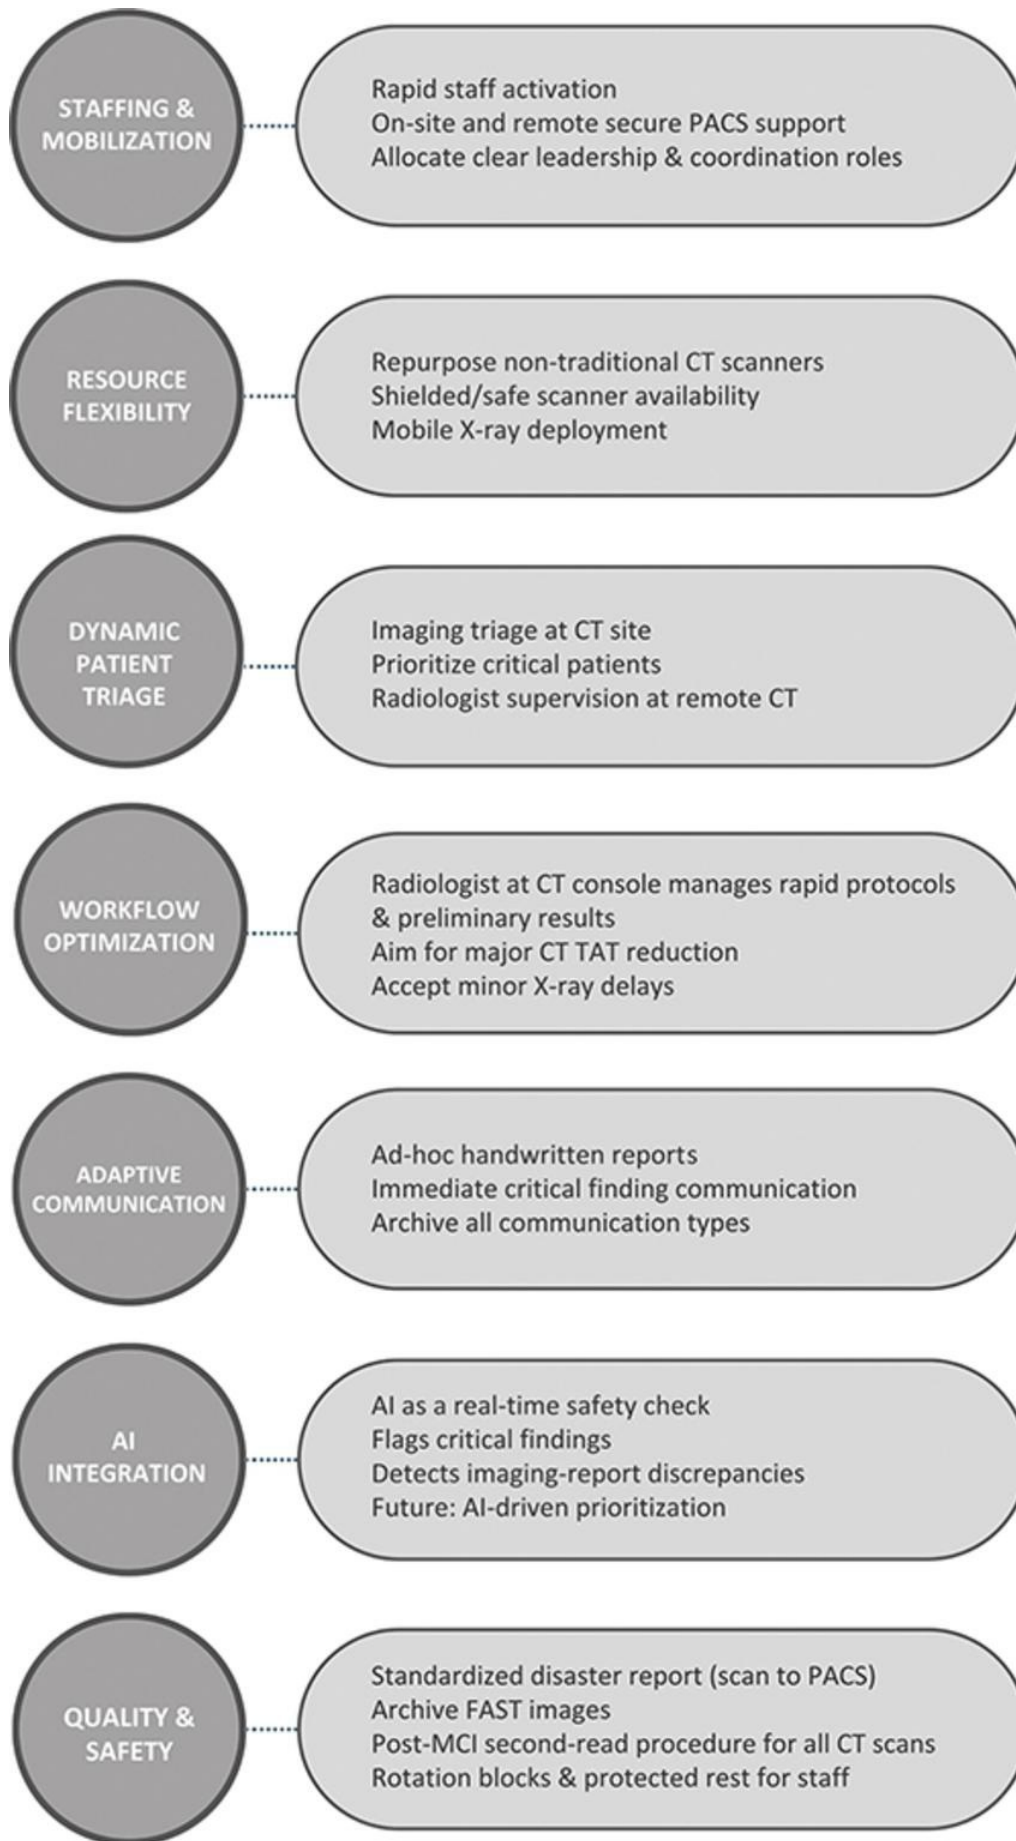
Preparedness checklist shows strategies implemented to maintain diagnostic quality and reduce turnaround times (TAT) under extreme patient surge conditions during an MCI. AI = artificial intelligence, FAST = focused assessment with sonography in trauma, PACS = picture archiving and communication system.
